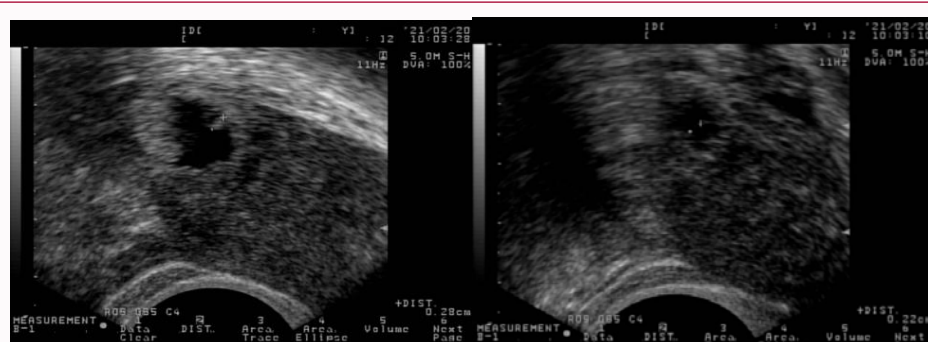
Transvaginal Ultrasound (TVS) scan showed gestational sacs in both cornua.
